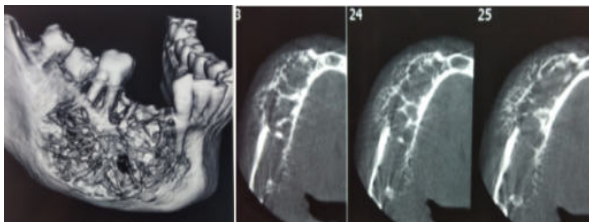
CBCT showing involvement of right body of mandible
